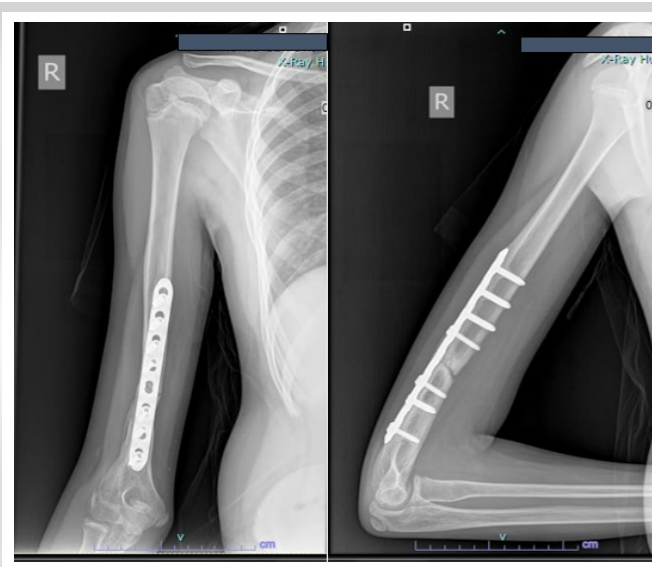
Radiograph at 8 months confirming non-union.
